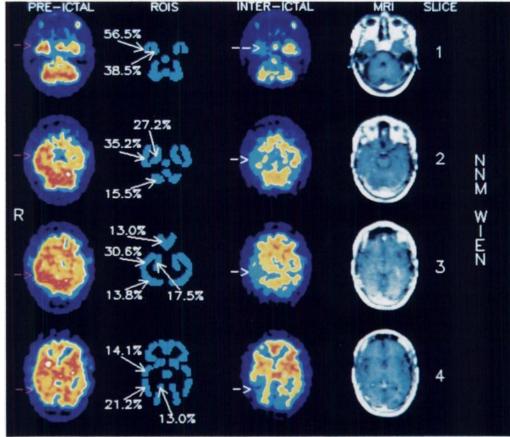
Preictal and interictal SPECT in Patient 1. Four adjacent, coregistered 10.35-mm-thick slices (rows) of preictal SPECT (first column from left), interictal SPECT (third column) and MRI (fourth column). The second column displays corresponding regions of interest with percentage increases of normalized regional cerebral blood flow (rCBF) values between the interictal and preictal condition (only increases above 12%, which were considered significant, are shown). Red and white arrows in the first and third columns from left indicate increased and decreased rCBF values, respectively. In the preictal scan, a significant increase of rCBF in the right temporal lobe (both mesial and lateral), right cerebellum, right orbito-frontal cortex and right anterioroccipital lobe can be seen.
